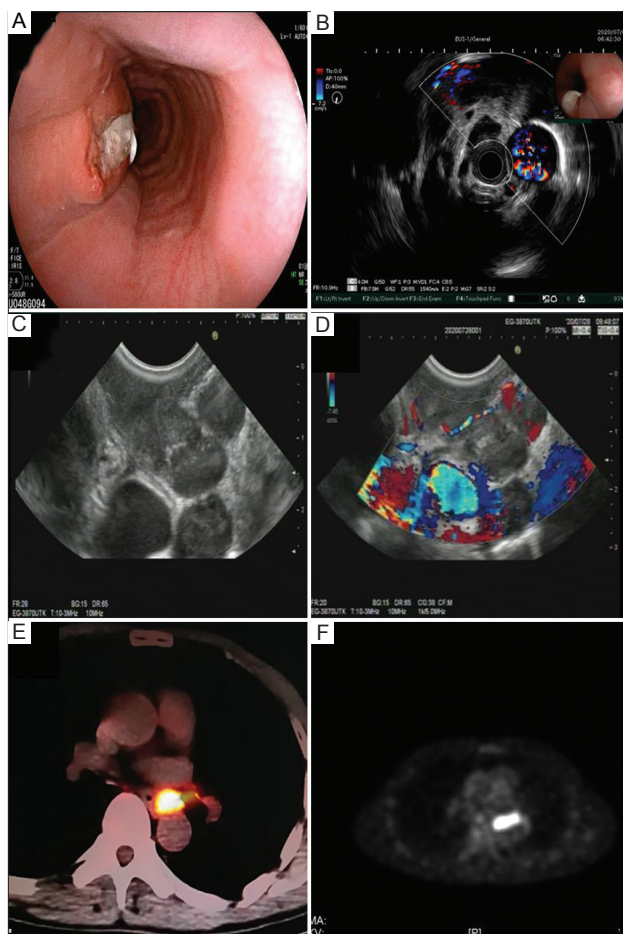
(A) Endoscopy of the lesion showed hemispherical eminence with approximately 2 cm × 2.5 cm base, a soft texture, and rupture in the lesion's central surface. (B-D) Endoscopic ultrasonography showed esophageal wall damage, low echogenic areas, partial disappearance of the esophageal boundary, scattered lymph nodes around the esophagus, and partial fusion. (E and F) Positron emission tomography-computed tomography examination showed thickening of local soft tissue in the middle and lower thoracic esophagus, high metabolic activity, and unclear boundary between soft tissue and left esophageal wall, suggesting a high possibility of malignant lesions.
